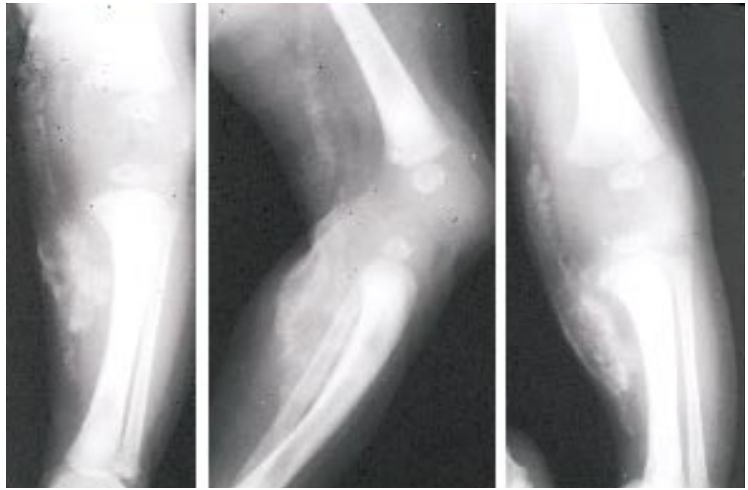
Radiographic series of an infant's leg with soft tissue and intravascular calcifications. This infant received calcium gluconate through a "cut-down" in the ankle. There are two patterns of calcification: amorphous ("bulky") and vascular (going up through the thigh).
